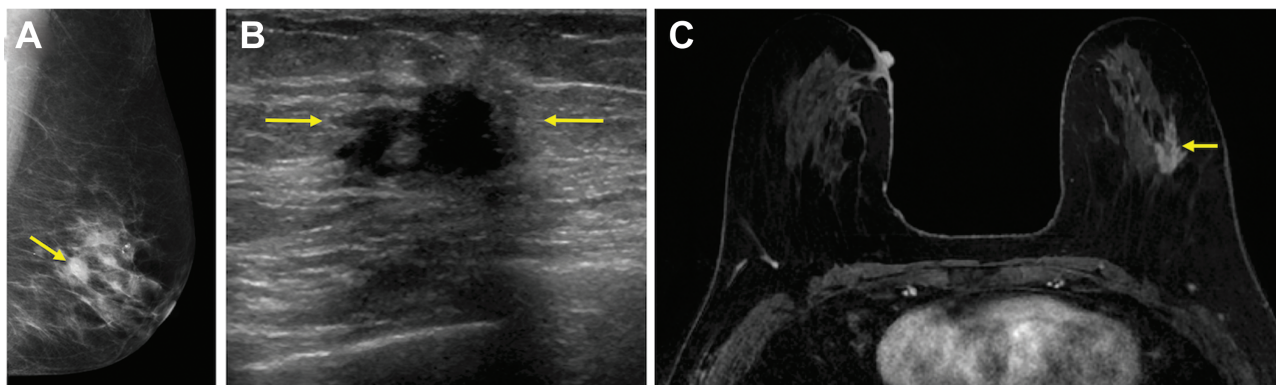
66-year-old woman who presented with a screening-detected mass in the left breast in the upper outer quadrant diagnosed on core-needle biopsy as invasive lobular carcinoma (ILC) (Nottingham grade II, estrogen and progesterone receptor positive, HER2-negative) with associated lobular carcinoma in situ, which serves as an example of overestimation of an ILC span on MRI with concordant depiction of span on conventional imaging. A: Diagnostic mediolateral oblique mammogram demonstrated an irregular-shaped mass with spiculated margins measuring 15 mm (arrow). B: Targeted US depicted an irregular mass with indistinct margins also measuring 15 mm (arrows). C: MRI performed after core-needle biopsy depicted the finding as an irregular mass with spiculated margins measuring 25 mm (arrow). Final pathologic size was 15 mm on mastectomy. MRI overestimated size by the 5 mm, 25%, and T category of stage thresholds, while conventional imaging was concordant using all three thresholds.
